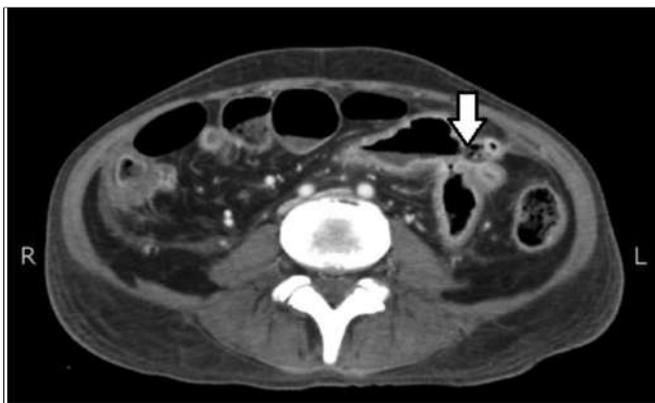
Axial post-contrast CT image of the same patient after 5 months of initial ischemic ictus, demonstrating coalescing small bowel loops showing enteroenteric fistula formation in left abdomen with stricture and enhancement.
